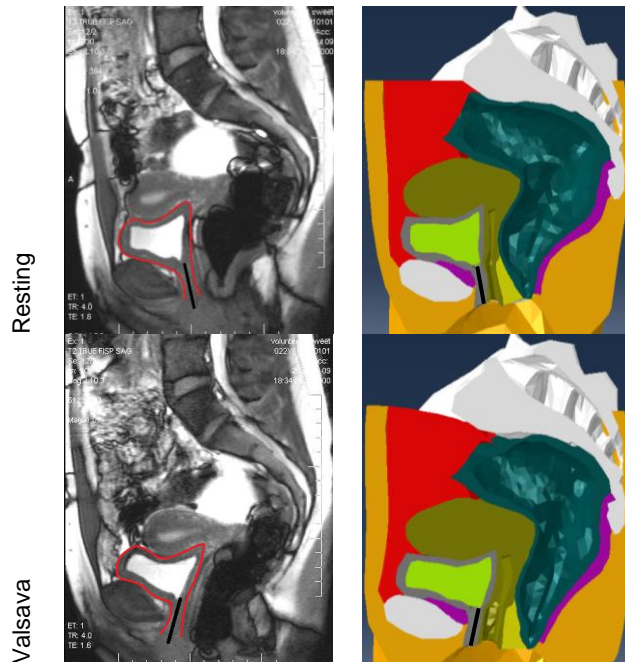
Comparison (dynamic MR scan Vs. Computational pelvic model) of the pelvic structure of the female subject in the sagittal plane, at resting stage and at Valsalva stage. The black solid line in all pictures show the position of urethra, and the red curves in the dynamic MRI show the outline of the bladder.
